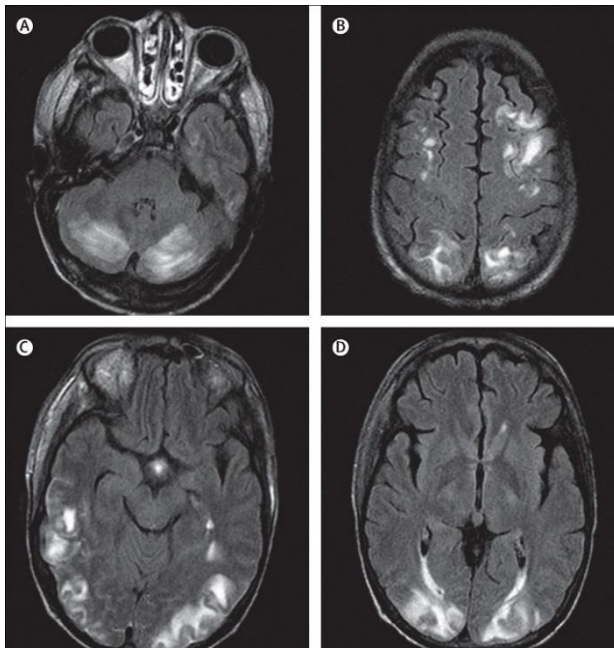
Typical MRI findings in PRES in axial T2 fluid-attenuated inversion recovery. MRI: magnetic resonance imaging, PRES: posterior reversible encephalopathy syndrome. *Source: The Lancet, Vol 14, Fugate, J.E.; Rabinstein A.A. Posterior reversible encephalopathy syndrome: clinical and radiological manifestations, pathophysiology, and outstanding questions, Pages No 914-925., Copyright 2015, with permission from Elsevier.*
